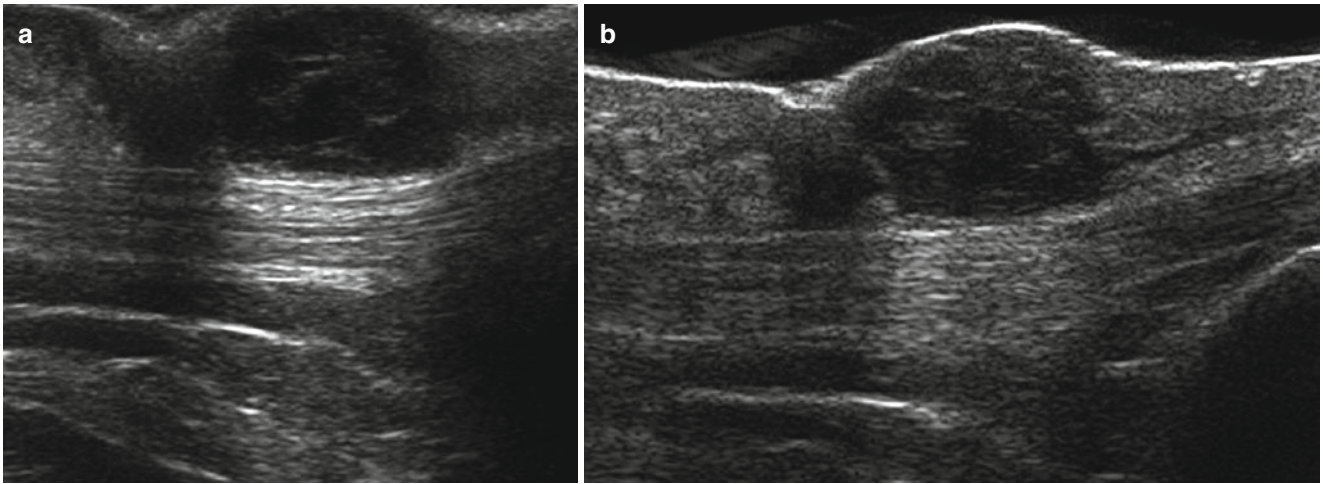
Post-surgical recurrence of a heel melanoma. Because of the protruding position of the nodule, the ultrasound image is fair (a). However, by using a gel pad spacer, it is possible to achieve an adequate depiction of the hypoechoic nodule (b)
